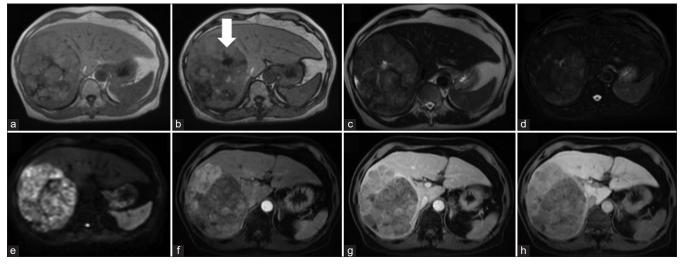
A 67-year-old male with hepatocellular carcinoma presenting with weakness, nausea, and vomiting. (a and b) T1 chemical shift abdominal MRI showed a heterogenous mass that appeared iso- to hyperintense during (a) in-phase along with signal loss during (b) opposed-phase (white arrow), indicating the presence of fat. (c) Hyperintense component of the mass was seen on T2-weighted sequence. (d) Part of the mass was suppressed on fat-saturation T2 sequence. (e) On DWI sequence, part of the mass had pathologic diffusion restriction. (f-h) Contrast administration showed enhancement during late arterial phase followed by washout and partly isointense appearance during delayed phase (g) without uptake during hepatobiliary phase (h). No contrast enhancement was found in the fat component.
